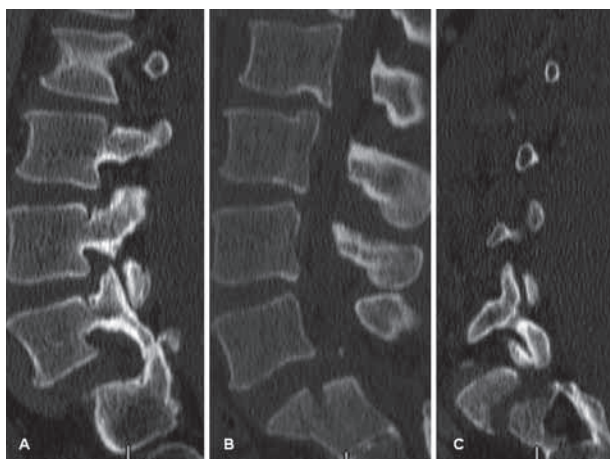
Sagittal CT reconstruction showing (A) left inferior articular process of L5 lying anterior to superior articular process of S1, (B) grade 2 spondylolisthesis of L5 on S1, widened interlaminar space and fracture of anterior body of S1, and (C) right superior articular process of S1 fractured at its base and displaced anteriorly along with the inferior articular process of L5.
